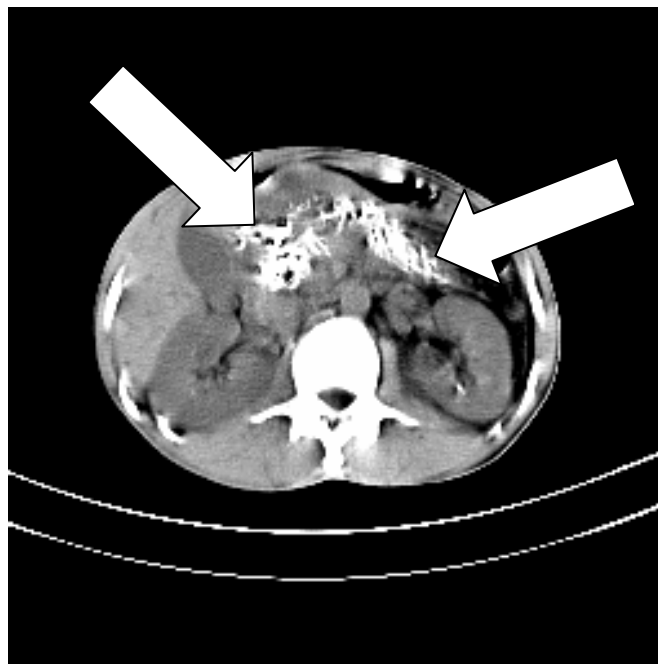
FIGURE # 5 : CONTRAST ENHANCED CT ABDOMEN AXIAL SECTION OF ARTERIAL PHASE SHOWING PSEUDOCYST IN PANCREATIC HEAD(ARROW).
